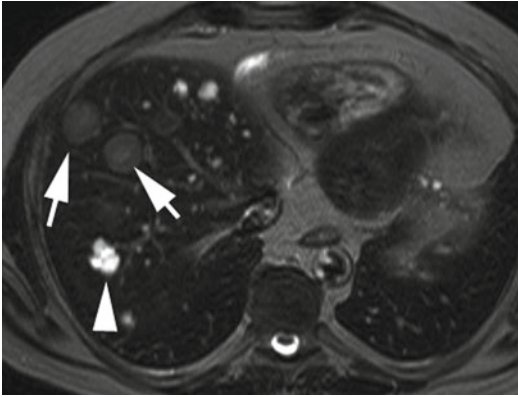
Liver metastases and cysts. T2-weighted axial MR in patients noted to have multiple hypointense lesions on CT. MR clearly distinguishes the marked high signal in cysts (*arrowhead*) and differentiates them from metastatic lesions (*arrows*)
